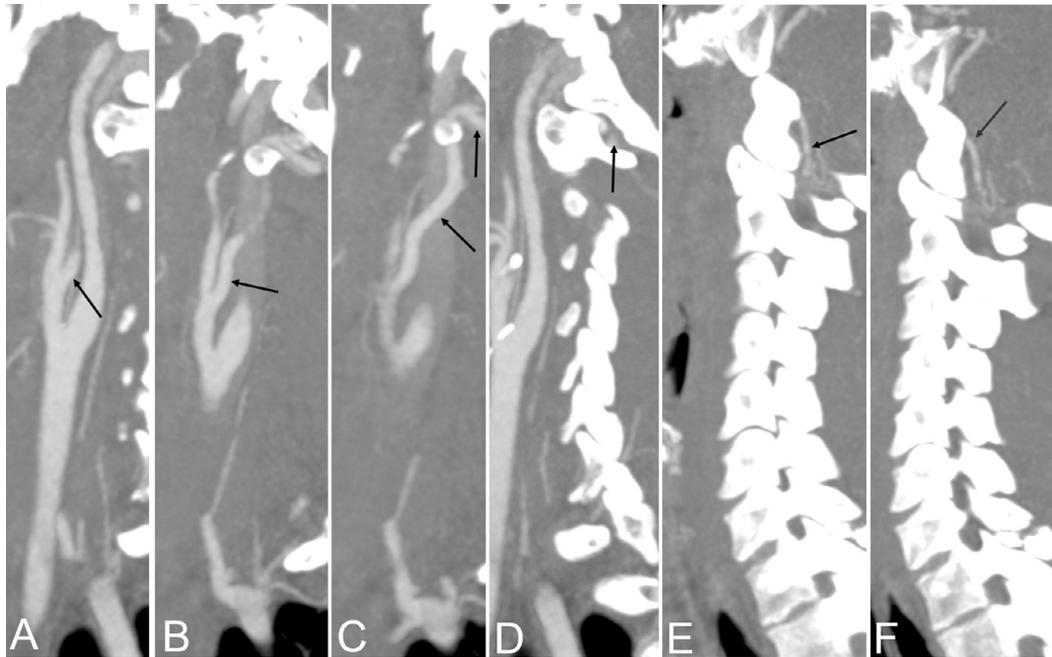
Computed tomography angiogram, sagittal (A–F) projection. The origin of a type II proatlantal artery from the proximal left external carotid artery at C3–C4 is seen (arrow) in (A–C). The vessel courses superiorly and traverses the C1 vertebra obliquely before constituting the distal left vertebral artery (D–F).
